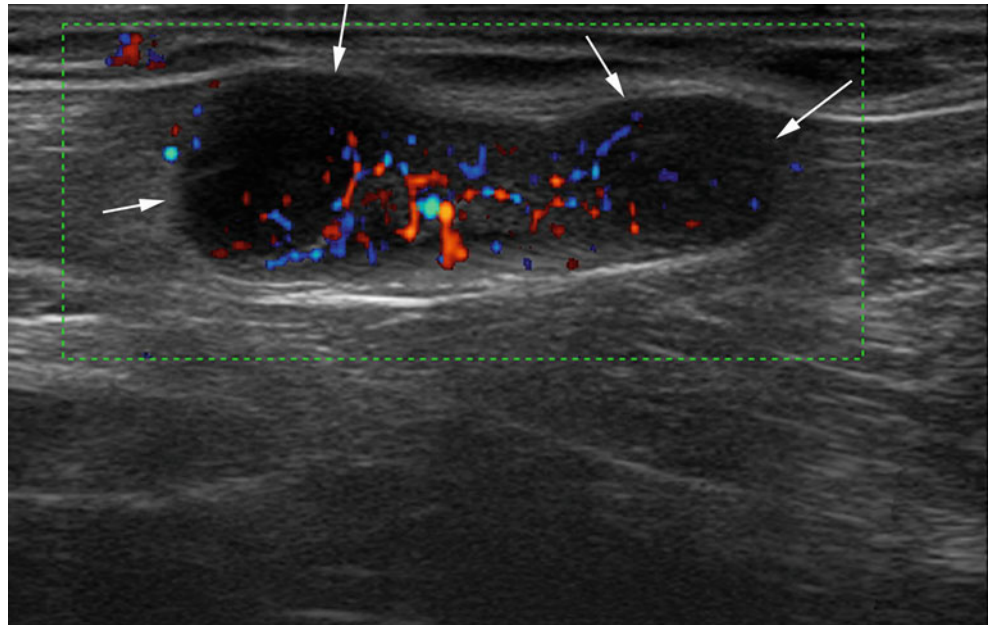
Focal lymph-node metastasis. Hypoechoic nodule within a lymph node placed between the breast and the axilla in a patient with previous abdominal wall cutaneous melanoma. Note multiple intranodular flow signals in the directional power Doppler part of the split-mode image
